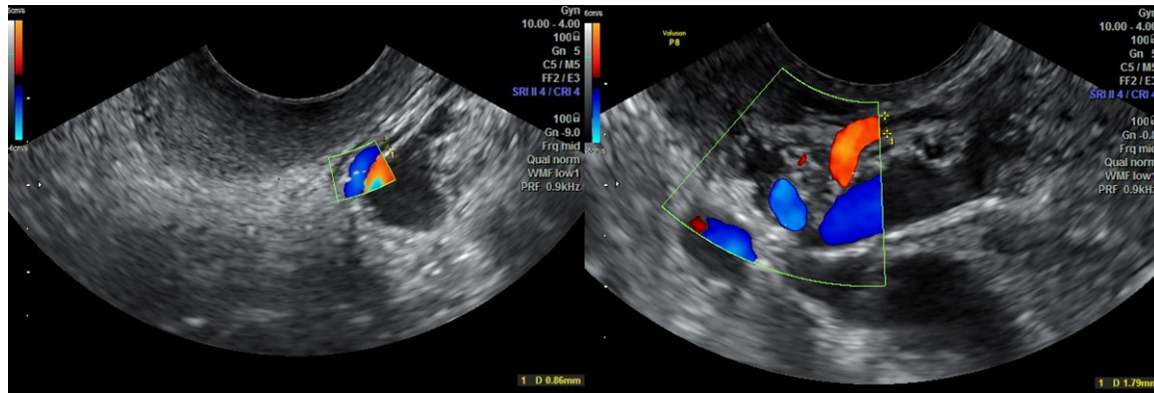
UtA diameters were measured on a perpendicular B-mode view of the longitudinal vessel section at maximum magnification. The lumen of the vessel was identified by colour power angiography and the diameter was measured on a gray-scale image after reducing the colour box by placing the calipers at the inner edges of the vessel itself at the specular reflection (Color doppler flow imaging and measurement of uterine vessel diameter for patient group in left side and for control group in right side).
